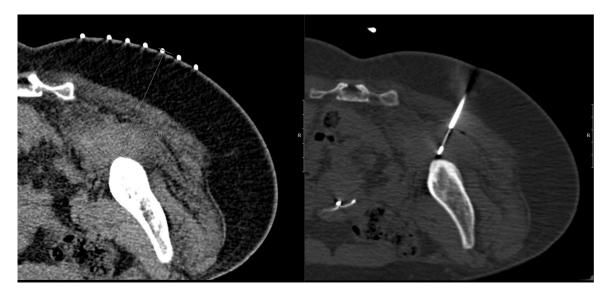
CT guided biopsy of the suspected mass located within the right sciatic notch. The biopsy results showed the presence of endometrial cells, stroma, and hemosiderin, confirming the diagnosis of endometriosis.
